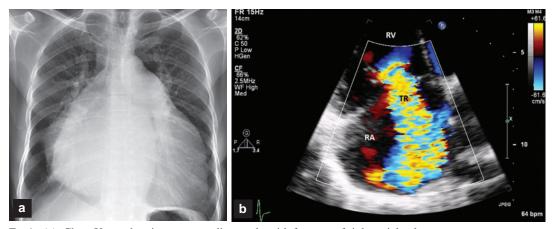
(a) Chest X-ray showing gross cardiomegaly with features of right atrial enlargement(b) Echocardiographic demonstration of severe tricuspid regurgitation due to non-coaptation of tricuspid valve leaflets, right ventricle
